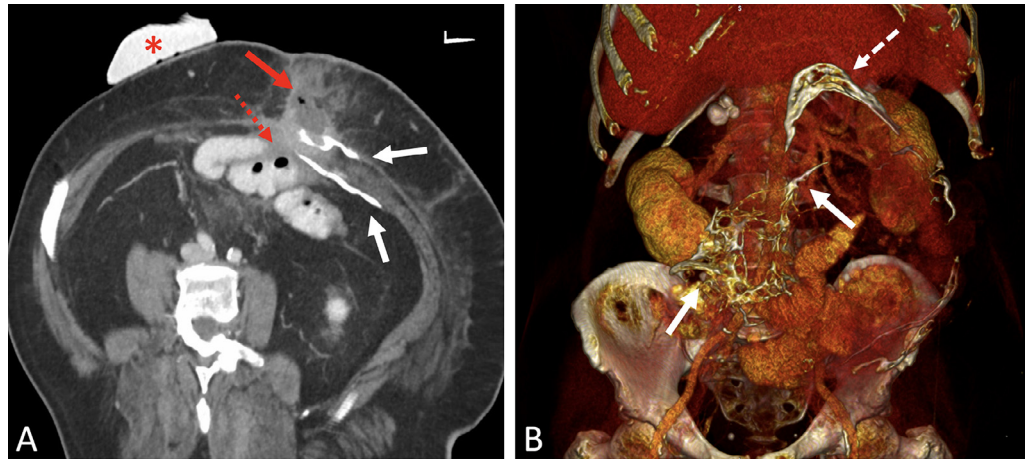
Bowel perforation and abscess. Transaxial CT scan (A) and 3-D rendering (B) acquired 5 years after the initial parastomal hernia repair. The areas of well-matured HMO are organized into arcades of jagged and lace-like structures (solid white arrows) as well as broad, semicircular sheets (dashed white arrow). Extraluminal gas and fluid related to abscess formation are seen in the anterior abdominal wall (solid red arrow) superficial to a defect of the small bowel (dashed red arrow). The bowel perforation lies immediately adjacent to two finger-like HMO projections. An ostomy bag is noted (*).
